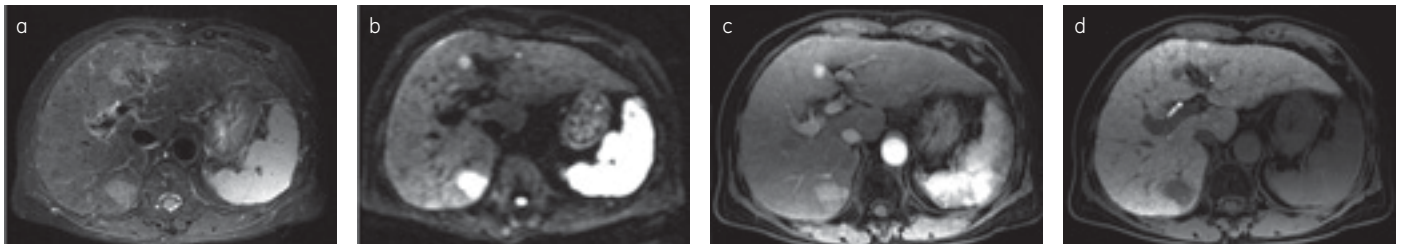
Hepatocellular carcinoma, Liver cirrhosis. All water images generated with LAVA Flex. (a) Respiratory triggered fat sat T₂WI. (b) Respiratory triggered DWI (b-value 800 s/mm²). (c) Breath-held Gd-EOB-DTPA enhanced water image in arterial phase with Smart prep. (d) Breath-held Gd-EOB-DTPA enhanced water image in hepatocyte phase.
